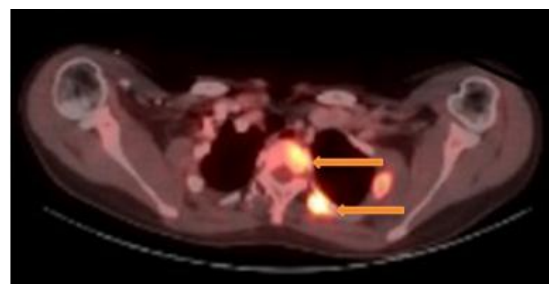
Osteolytic lesions in spine with adjacent rib in CT thorax.
